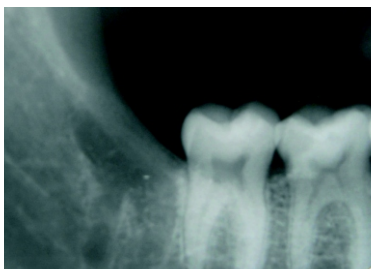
Post operative (15 days) radiograph of control (non graft) site
